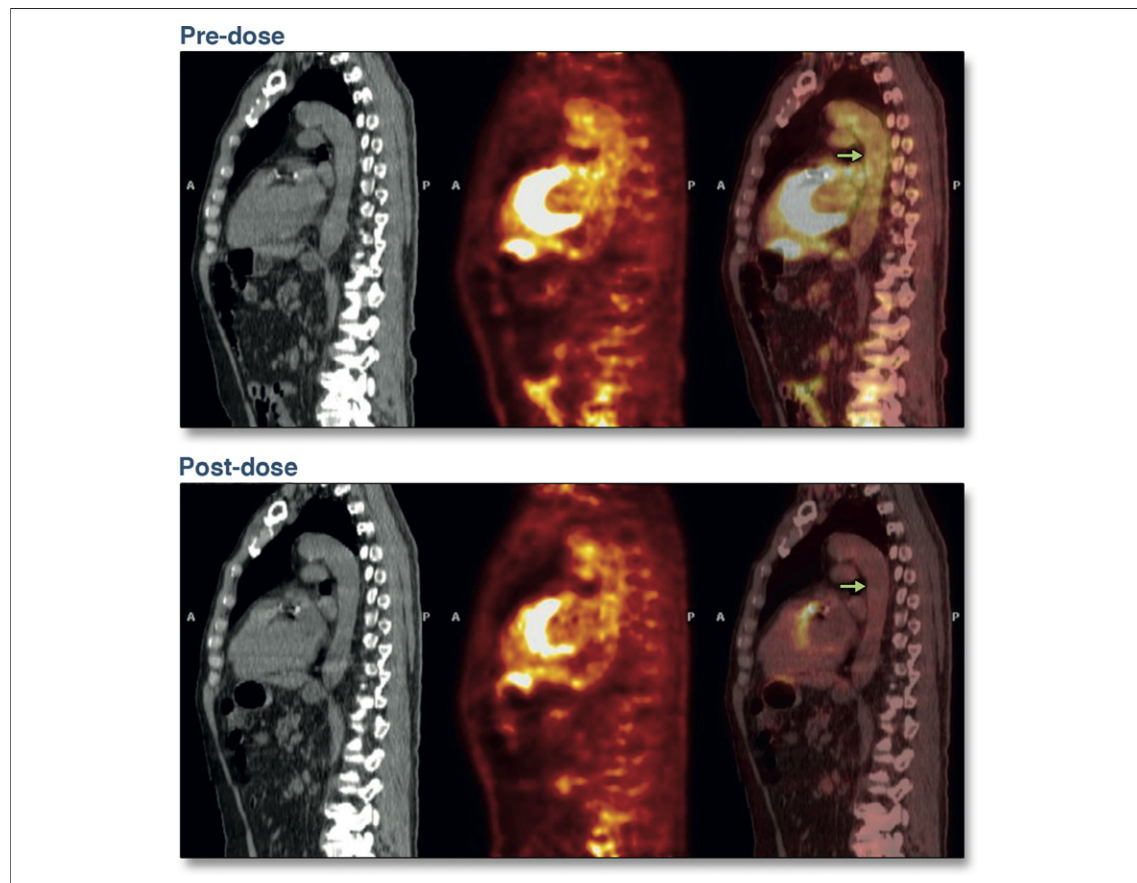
Typical FDG-PET/CT Images
